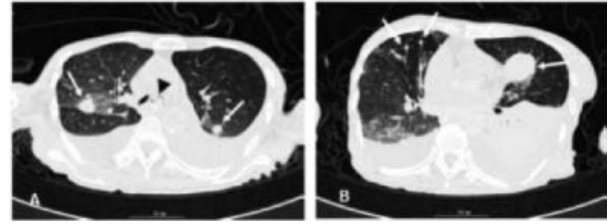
Chest computed tomography, patient 77 died of pulmonary metastasis. (a) Evidence of abnormal endobronchial mass; (b) evidence of bilateral pleural effusion. Source: Taken from Takahashi *et al.*^[58]
